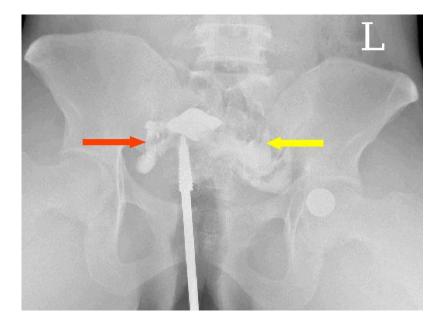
A frontal radiograph of a hysterosalpingography showing free intraperitonial spillage bilaterally (right spillage red arrow, left spillage arrow) suggestive of bilateral tubal patency.
